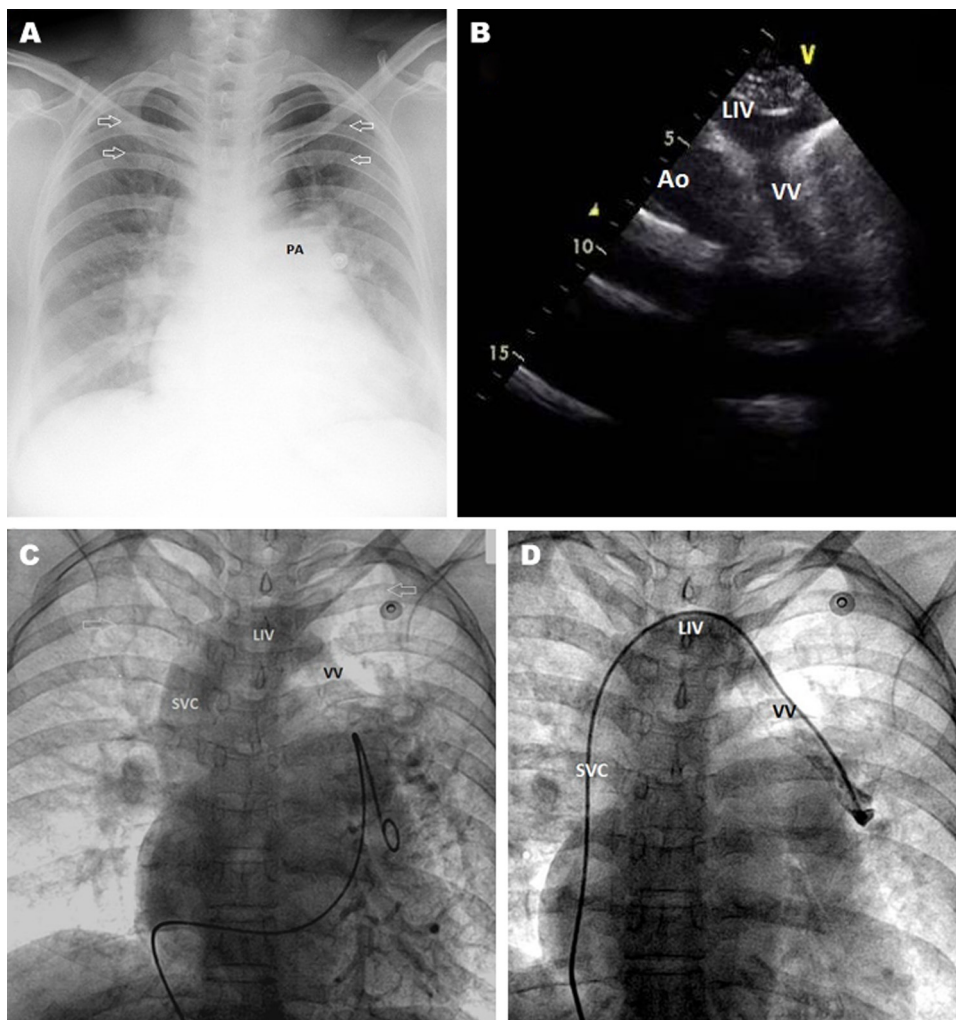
(A) Chest radiograph (PA-view) showing main pulmonary artery dilatation (PA) and unilateral upper lobe venous prominence (cephalisation) on the right side (arrows). (B) Echocardiogram (high left parasternal window in the transverse view) showing partial anomalous pulmonary venous connection (PAPVC) of the left upper pulmonary vein (LUPV) to the left innominate vein (LIV) via a vertical vein (VV). (C) Levophase for pulmonary venous return showing PAPVC of left upper pulmonary veins connecting to the left innominate vein with subsequent drainage to the right superior vena cava (SVC) and to the right atrium. (D) Direct injection into partial anomalous PAPVC of the LUPV to the LIV and to the right SVC via a (VV).
